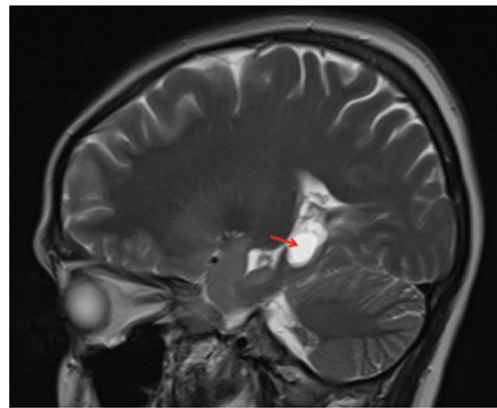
MRI scan of the patient brain showing multilobulated cystic mass (red arrow).
